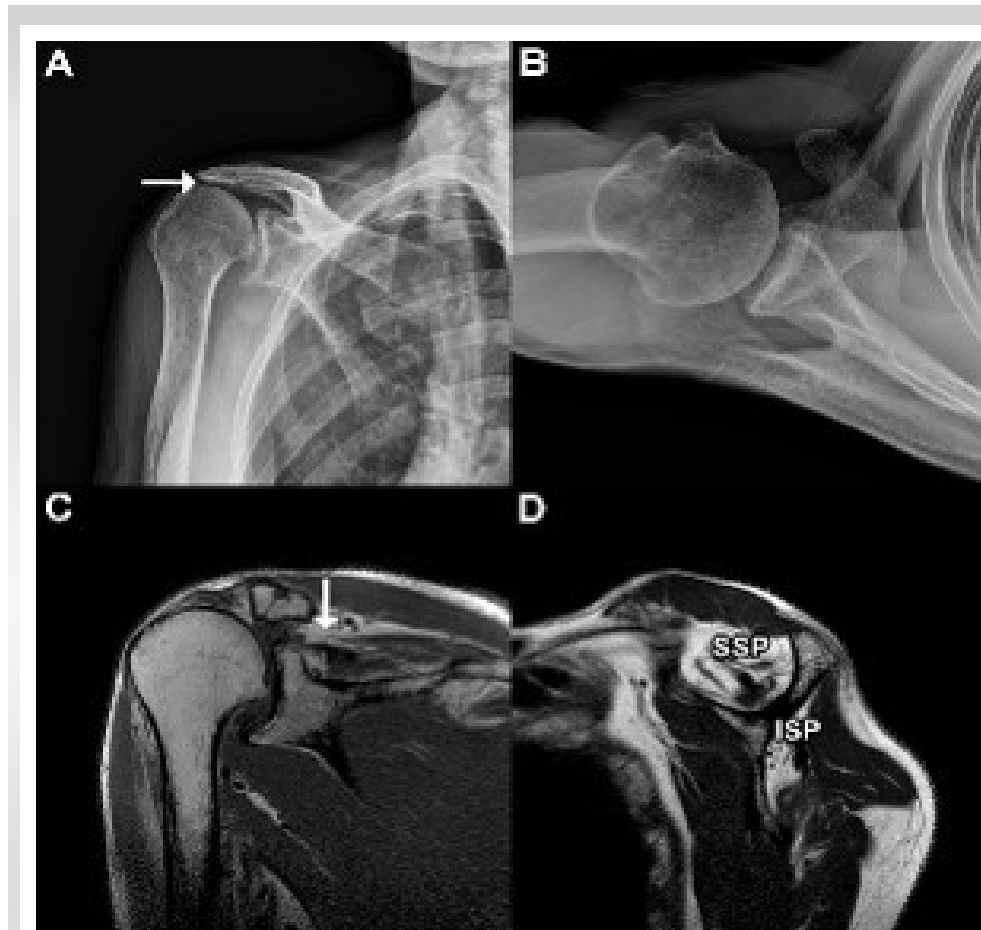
Pre-operative radiograph and magnetic resonance imaging (MRI). Pre-operative radiograph of the right shoulder shows superior translation of humeral head (white arrow) and minimal arthritis in (A) true anterior-posterior view and (B) axial view. (C) The pre-operative MRI of the right shoulder demonstrates the supraspinatus tendon (white arrow) retracted medial to the level of the glenoid in coronal-view MRI and (D) shows severe fatty infiltration and atrophy of both supraspinatus and infraspinatus muscles in sagittal-view MRI.
